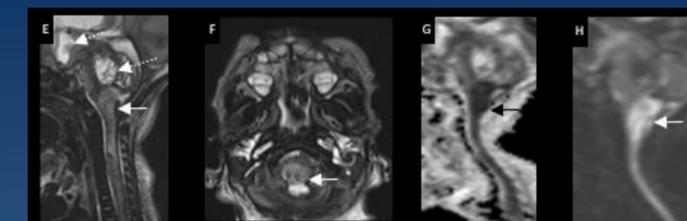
(Patient 2): Sagittal and axial T2 weighted images (E, F) show diffuse swelling and hyperintensity of the medulla, cervical and thoracic spinal cord; and extensive debris in the 3rd and 4th ventricles (dotted arrows in E). Sagittal DWI and ADC (G, H) images show medullary and spinal cord infarction. Note "tumefactive" swelling of the cervicomedullary junction (arrows, E-H).
